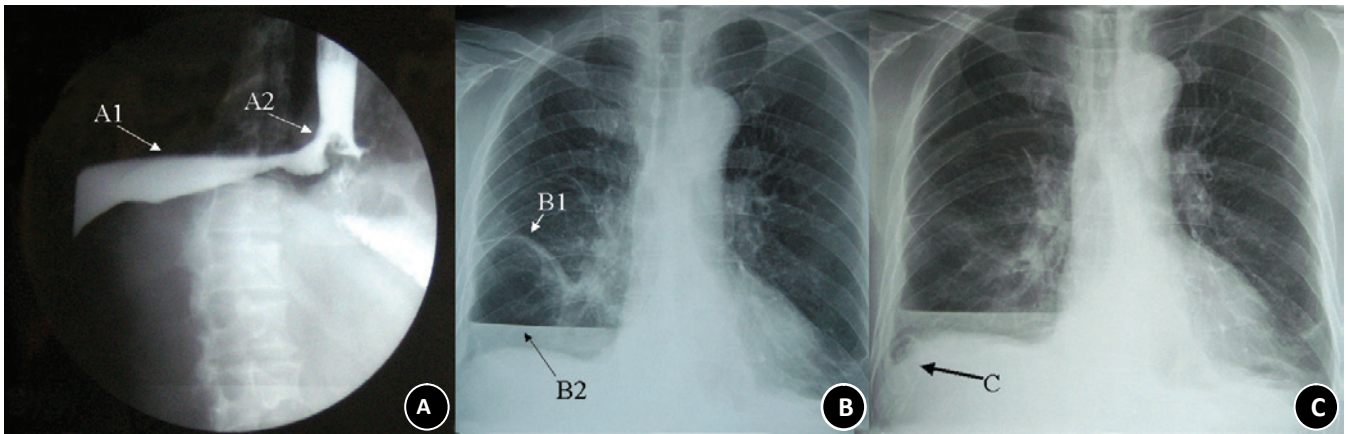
A contrast radiograph (A) and a plain radiograph (B) on day 18 after the operation, and a plain radiograph (C) on day 20 after the surgery. In the image A, the contrast medium (arrow A1) is traced from the orifice (arrow A2) into the right thoracic cavity. In image B, the right fissura interlobaris (arrow B1) is visible, and the fistulae fluid and contrast medium (arrow B2) accumulate in the right thoracic cavity. In image C, a drainage tube (arrow C) is percutaneously placed into the right thoracic cavity directed by ultrasonography.
